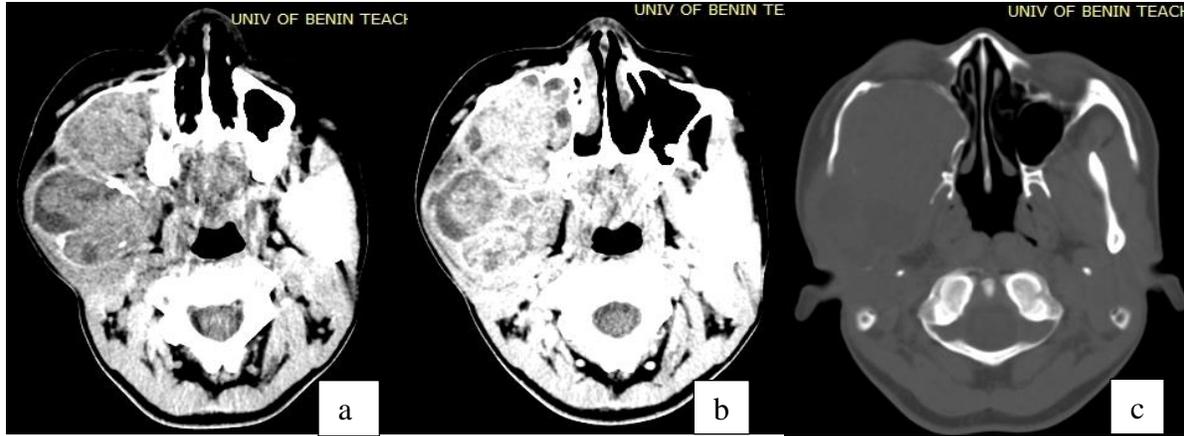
Ameloblastic carcinoma: Axial unenhanced (a) and contrast enhanced (b) computed tomographic images show a large ill-defined, predominantly solid heterogeneously enhancing mass with lytic destruction of the right maxilla. There are multiple hypoattenuating areas suggestive of necrosis. The lytic destruction of the right maxilla and mandible is well depicted on bone window level (c).
